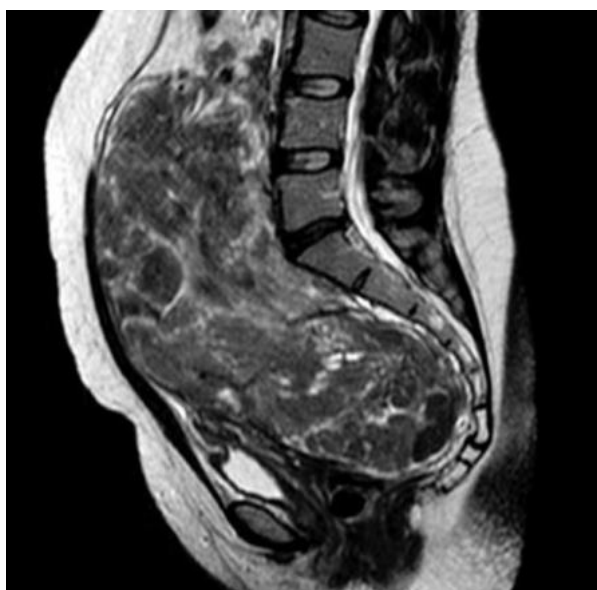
Sagittal plane MRI of the giant cervical fibroid.
